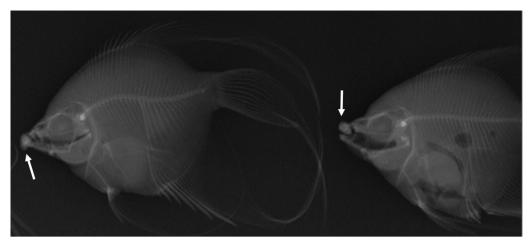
Radiograph of two angelfish with an odontoma. Radiopaque protuberances are observable on the rostral region of the fish. These correspond to the macroscopically observed tumorous mass in the mouth (arrow).
